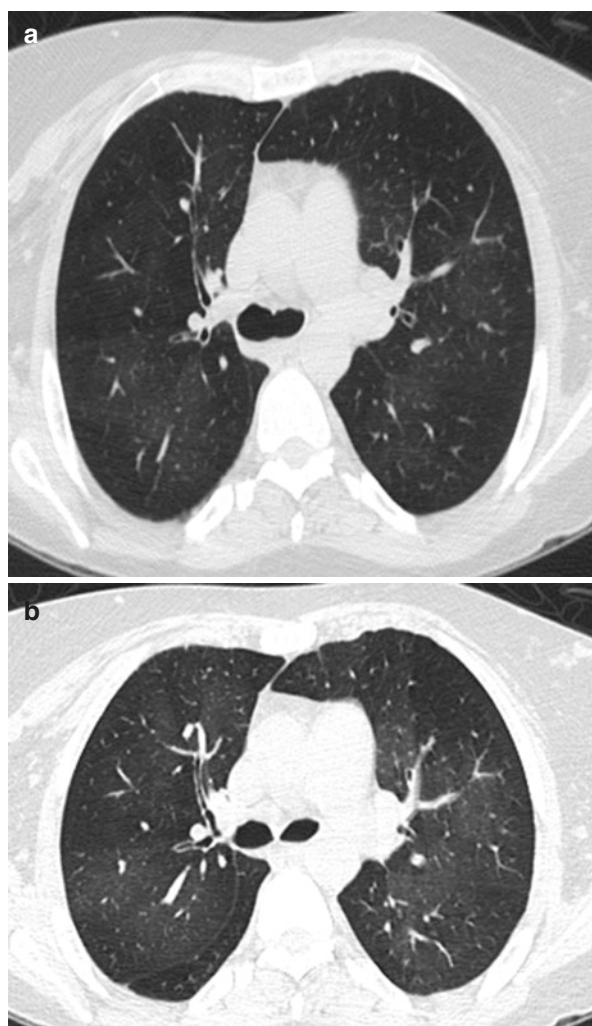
High-resolution computed tomography scan of the chest on a 33-year-old woman, nonsmoker, with a 12-year history of rheumatoid arthritis and progressive obstructive lung disease from constrictive bronchiolitis. Mosaic pattern due to patchy air trapping seen on inspiratory view is accentuated on expiratory view. Her total lung capacity measured was 115% predicted, residual volume 210% predicted, forced vital capacity (FVC) 79% predicted, forced expiratory volume in 1 s (FEV1) 35% predicted, FEV1/FVC ratio 37%, and diffusing capacity 89% predicted
